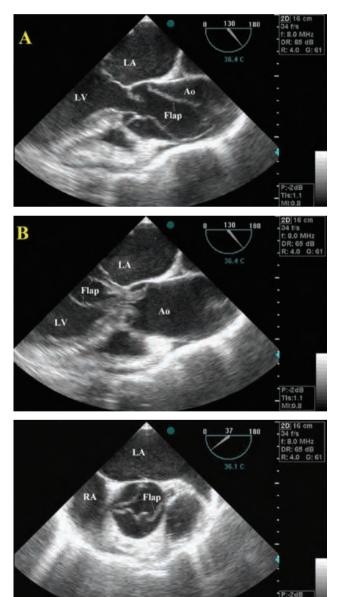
(A) Transesophageal echocardiography midesophageal aortic valve long-axis view of type A aortic dissection, The intimal flap prolapsing into the aortic root during systole. (B) Transesophageal echocardiography midesophageal aortic valve long-axis view of type A aortic dissection, The intimal flap prolapsing into the left ventricle during diastole. (C) Transesophageal echocardiography midesophageal aortic valve short-axis view showing the intimal flap.
